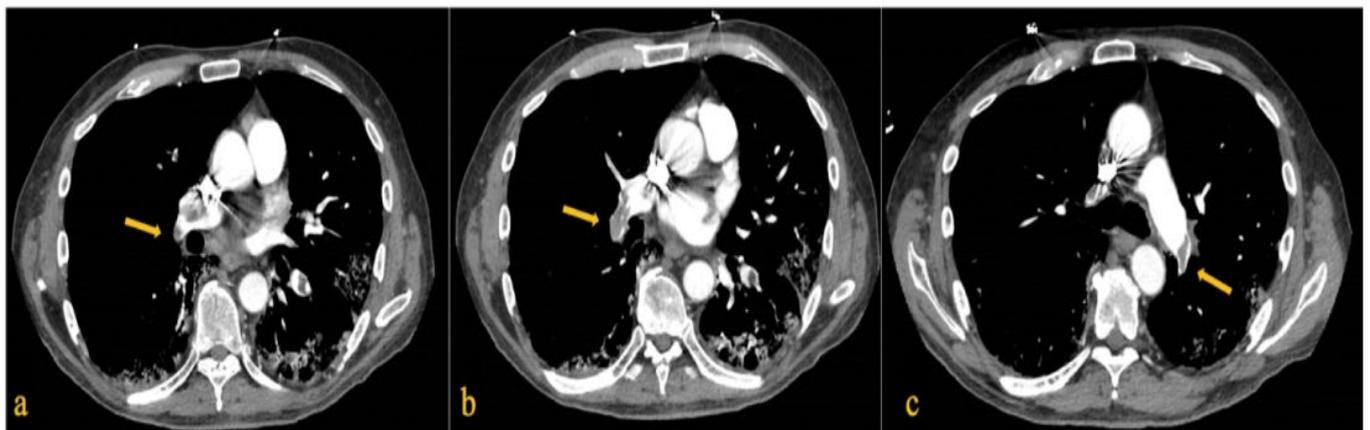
Chest computed tomography shows pulmonary emboli in the right pulmonary artery (a and b) and left pulmonary artery (c) with significant clot burden.
